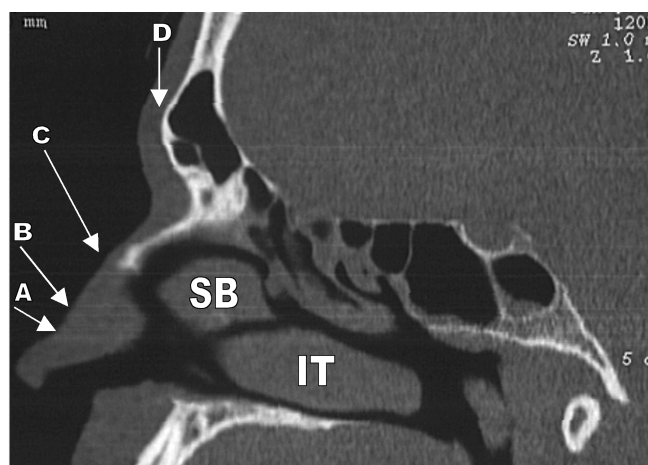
Parasagittal CT reconstruction showing relation of the nasal swell body (SB) to the inferior turbinate (IT). In this section, the SB and IT are seen at the distal aspect of the nasal valve region. At different parasagittal planes these structures extend further anteriorly into the valve region. Arrows marked A, B, C, and D indicate angles of modified coronal CT reconstructions shown in Fig. 3.
